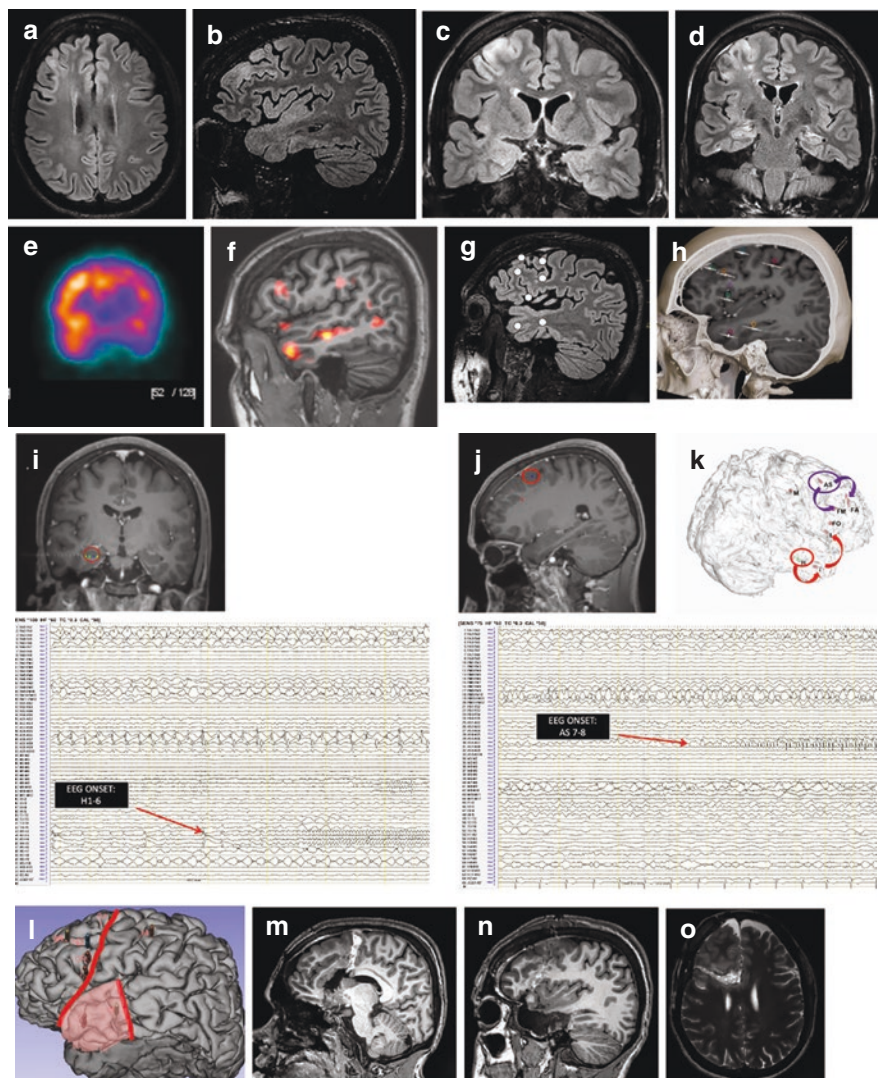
A 16 years old with a focal motor epilepsy refractory to ASD, started at the age of 8. VEEG showing signs of involvement of the right hemisphere and right temporal lobe. (a–d) Preoperative FLAIR-weighted MRI scans showing hyperintense abnormalities over the frontal and temporal lobes; (e) Ictal SPECT depicting hyperflow in the fronto-temporal region; (f) SISCOM showing hyperflow in the fronto-temporal region. (g and h) SEEG planning with the insertion of electrodes in the suspected frontal and temporal regions and (h) post implantation MR confirming the exact location of the electrodes. (i and j) MRI scans showing the exact location of seizure onset as depicted in EEG registration (lower images) in the temporal and frontal regions; (k) spreading of seizures in the temporal and frontal region. (l–o) planned and performed frontal lobe disconnection and temporo-mesial resection. Pathology: cortical dysplasia type 1
